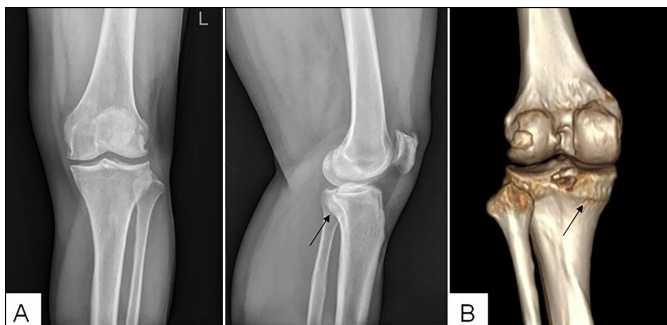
Preoperative imaging. (A) Preoperative anteroposterior and lateral knee radiographs demonstrating an avulsion fracture at the tibial insertion of the posterior cruciate ligament. (B) Preoperative 3-dimensional CT reconstruction reveals comminution of the fracture fragment.
